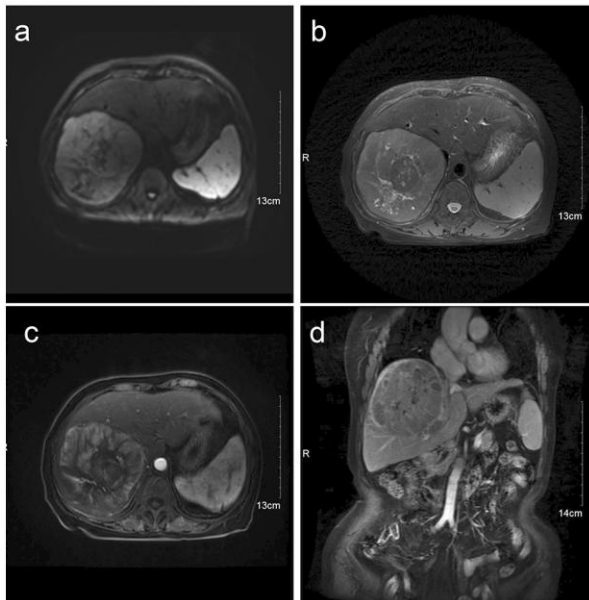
Patient A receiving cTACE treatment. Contrast-enhanced MRI images of a huge hepatocellular carcinoma (13.5 cm) in the right lobe before the first session of treatment. (a)DWI. (b)T2WI. (c) Axial, TIWI with contrast-enhanced MRI, arterial phase. (d) Coronal, TIWI with contrast-enhanced MRI, arterial phase.
